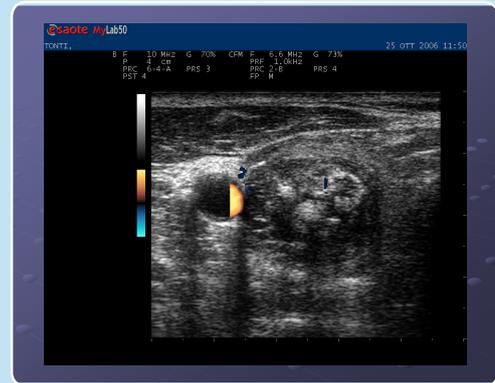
Post treatment color doppler ultrasound that show absence of vascularization
